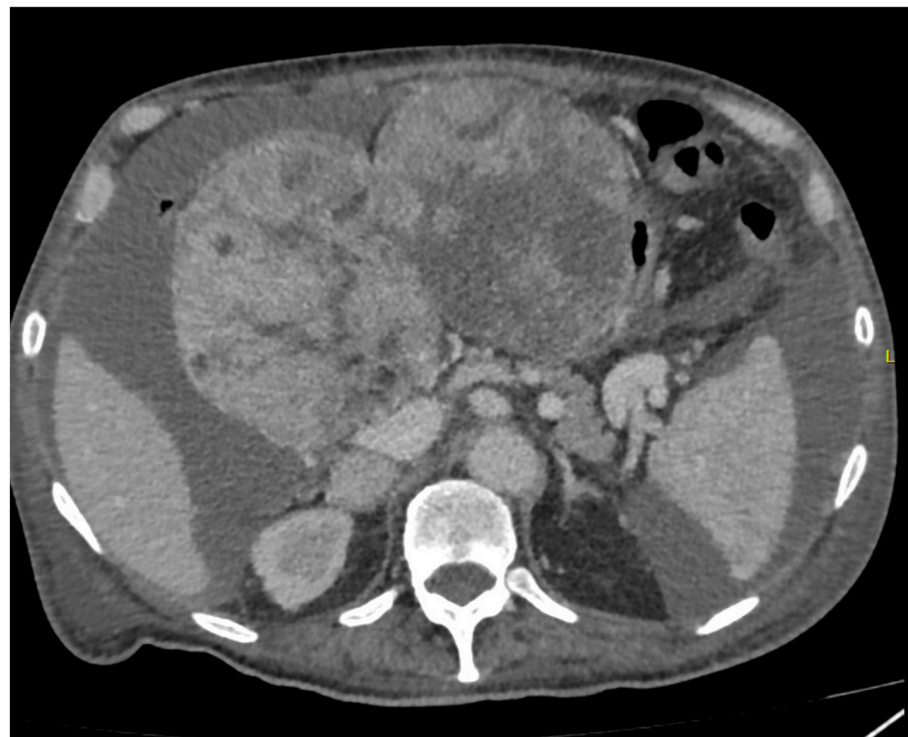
(A) Abdominal MRI showing a large bilobed necrotic hepatic mass measuring $19.1 \times 17.7 \times 10.3$ cm (TR \times CC \times AP dimensions) replacing the entire left hepatic lobe with mass effect and left portal and hepatic veins thrombosis/occlusion with severe narrowing of main portal vein and signs of portal hypertension. (B) Abdominal CT angiography showing new ascites and new hyperdense components adjacent to the liver. New hemoperitoneum, likely caused by spontaneous rupture of the patient's known hepatic mas.
